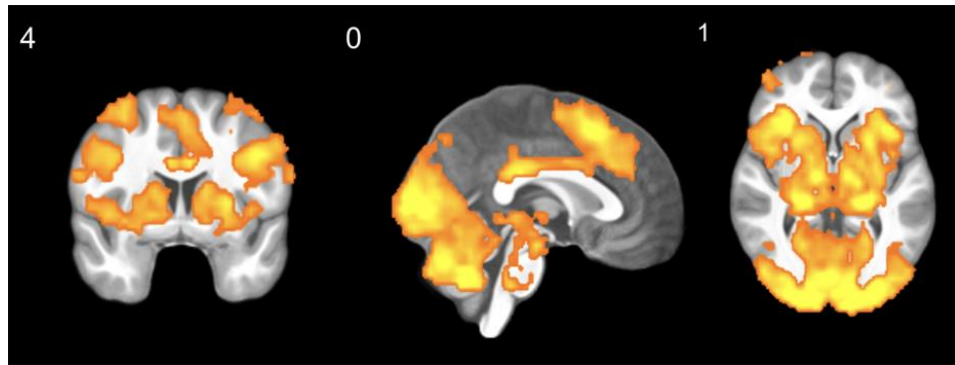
Mean activation during choice (N = 21) overlaid on the mean participant T1-weighted image in standard space, whole brain cluster-forming threshold $Z > 2.3$, cluster-corrected $p < .05$.
